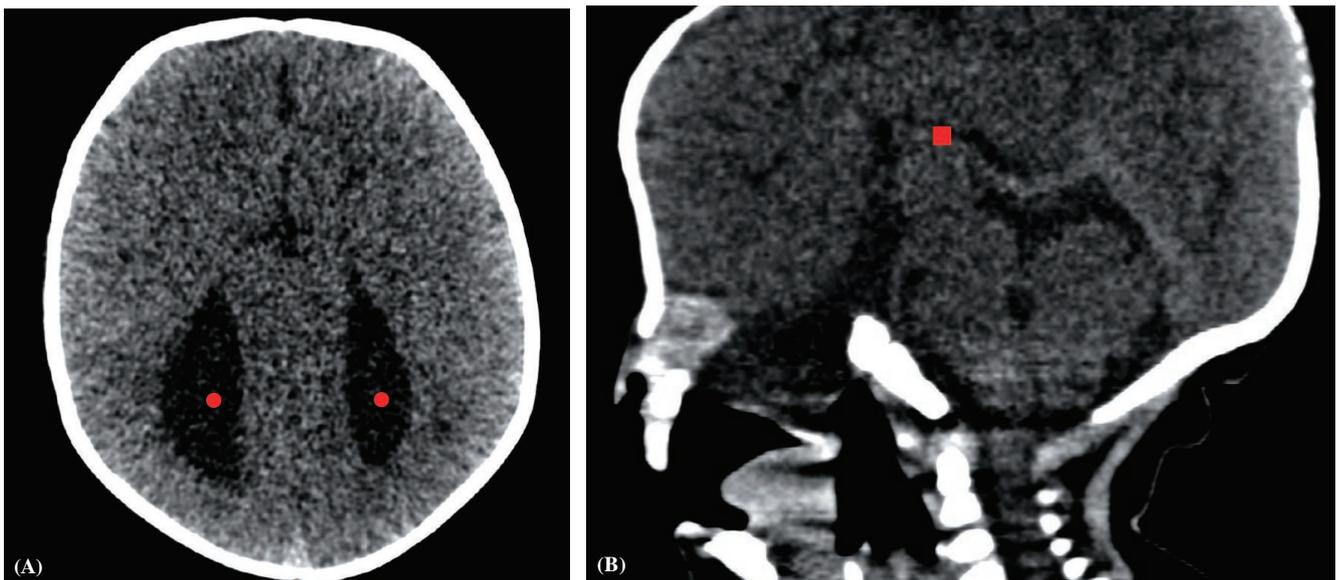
Facial CT, brain window: (A) Axial image showing parallel configuration of the lateral ventricles with disproportionate body and atrial dilatation (red solid circle). (B) Sagittal CT reconstruction showing the radial configuration of the gyri, with absence of the corpus callosum (red solid square)
